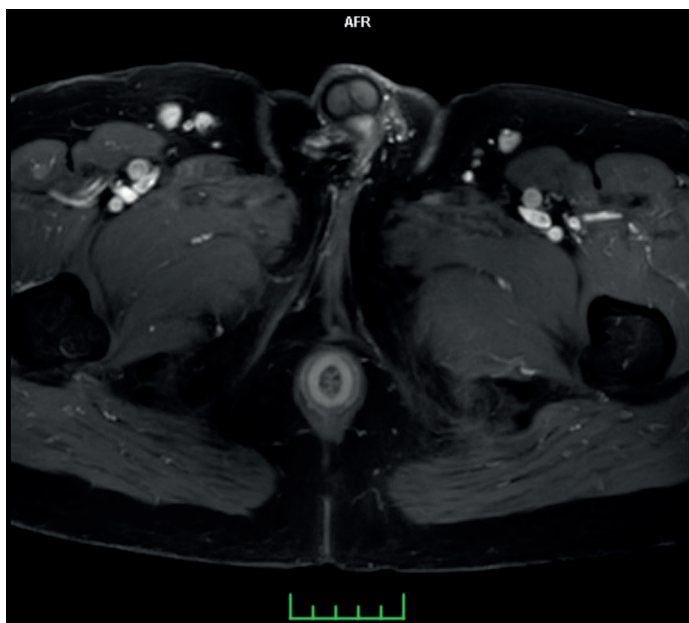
Pelvic MRI. The tumor with anal margin localization is not associated with internal and external sphincters. In the right inguinal superficial region, several lymph nodes with benign character can be seen.
